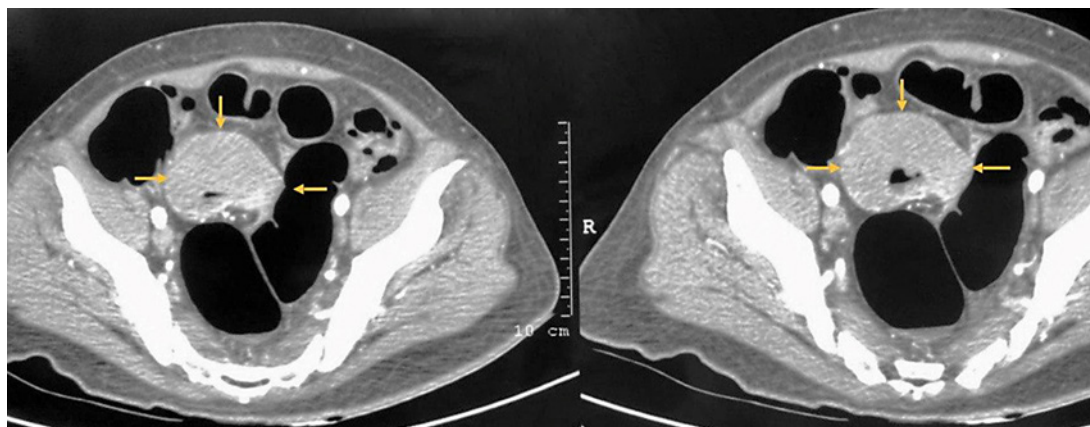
Abdominal CT showed terminal ileum wall thickening (arrows).
